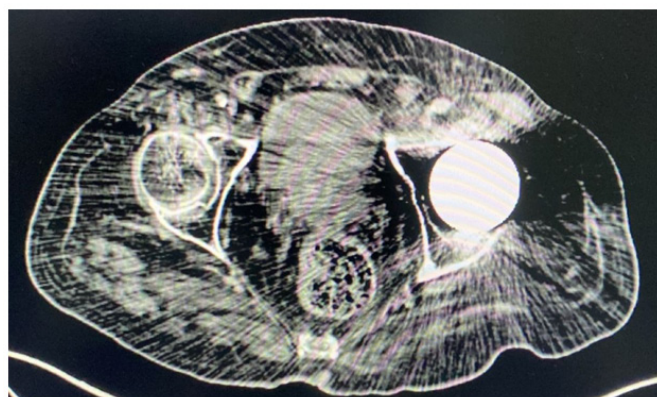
Images on a SIEMENS BIOGRAPH MCT equipment with diagnostic computed tomography with multidetection helical mode.
